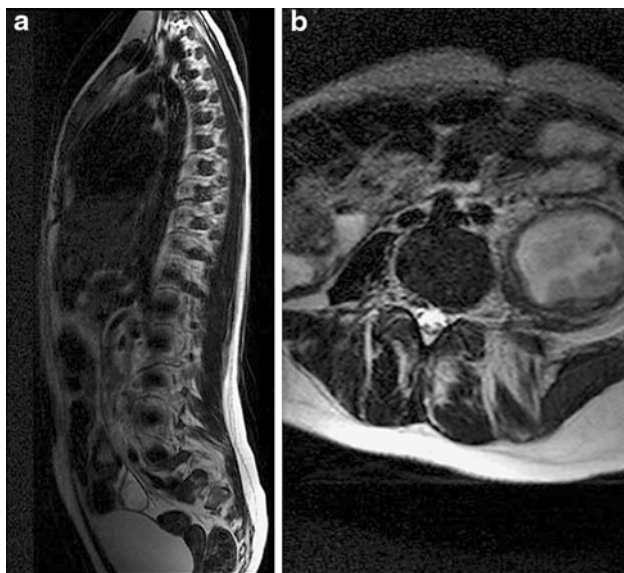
a Sagittal MR image, a large psoas abscess, definitive diagnosis was made microbiologically. b At same patient, axial MRI image demonstrating a left cold psoas abscess
